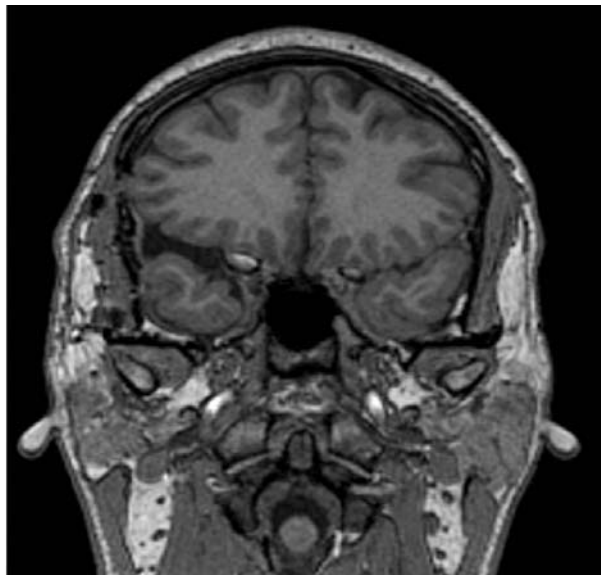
Postoperative native coronal MR T1-weighted image shows almost complete volume regain of the right temporal lobe gyri and sulci following arachnoid cyst fenestration.
